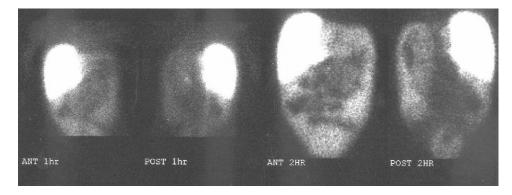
Hepatobiliary scintigraphy demonstrating intense perihepatic tracer accumulation resulting from a biliary leak. Note photopenia representing loops of bowel made apparent by tracer activity within the peritoneal space seen most prominently on 2-h delayed images.
